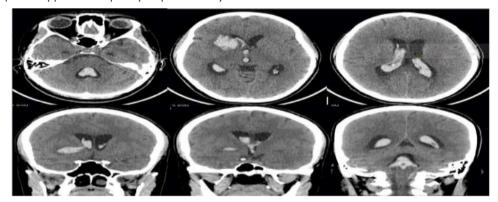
Non-contrast brain CT Scan (upper raw axial wiew and below raw coronal view) demonstates acute hemorrhage as hyperdens—signal intensity at right nucleus caudatus, right anterior crus of internal capsule with intraventricular hemorrhage (entire ventricular system) with minimal midline shift to the left.
